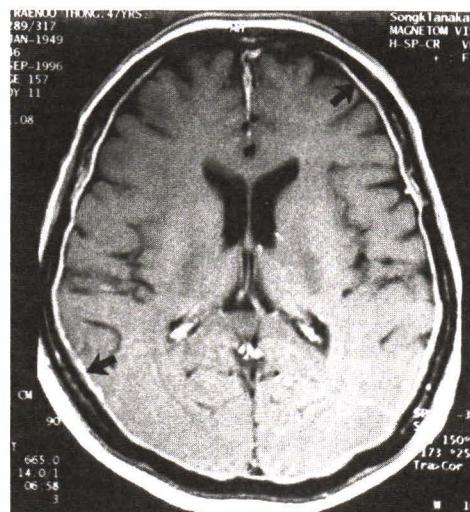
Axial T1-weighted gadolinium-enhanced MRI showing diffuse enhanced meninges (straight arrows).
